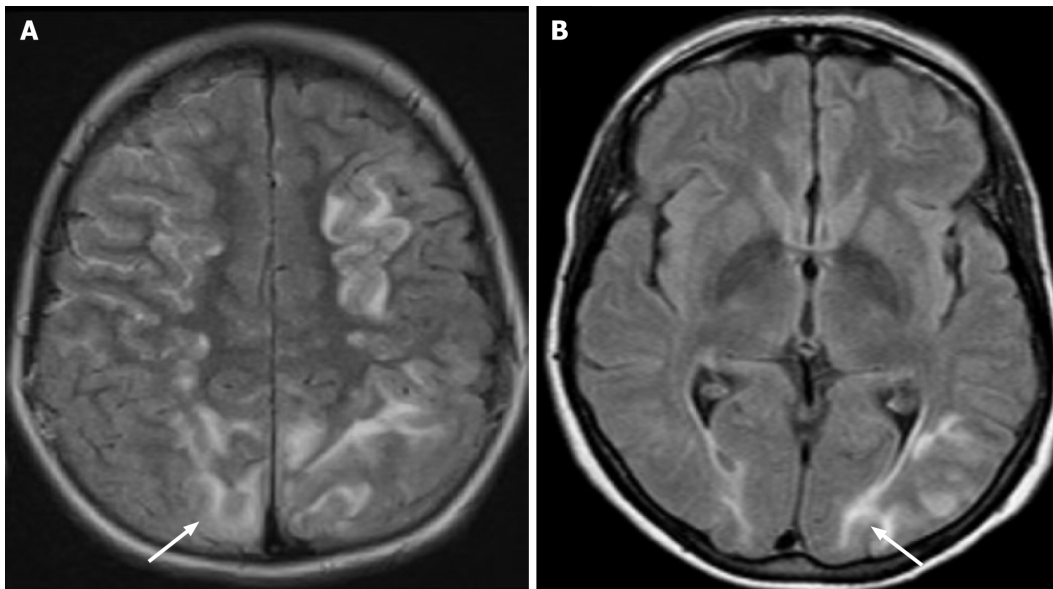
Magnetic resonance imaging of the brain (Axial Fluid-Attenuated Inversion Recovery sequence imaging) showing bilateral cortical and subcortical hyperintense lesions (arrows) involving occipital lobes and parietal lobes. A: Hyperintense lesions in the parietooccipital sulcus (white arrow); B: Hyperintense lesions at the transverse occipital fasciculi (white arrow).
